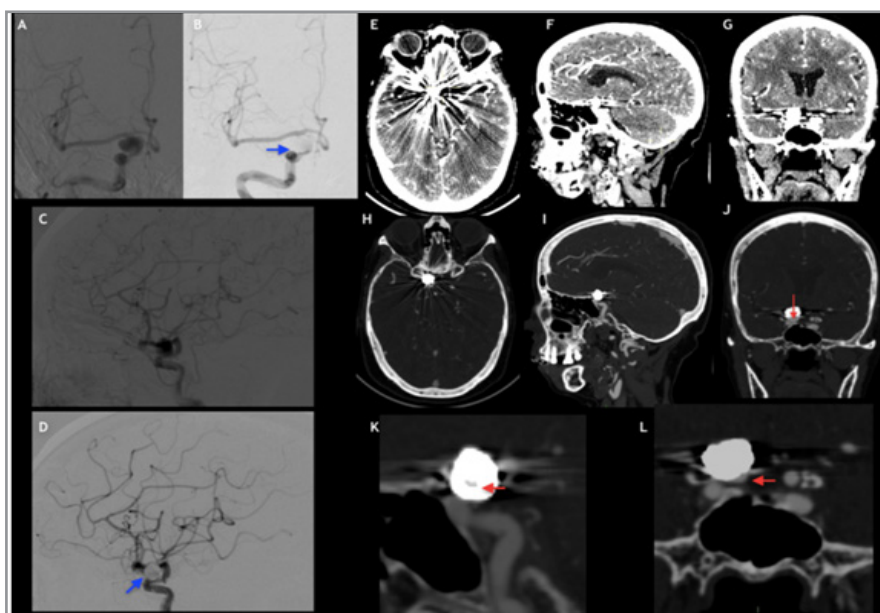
CTAMaR - DSA Discrepancy: A-D: DSA showing right paraclinoid aneurysm. Before embolization (A, C) and 3 months post-embolization (B, D). No evidence of residue/recanalization (arrow in B and D). E-G: CTA with traditional technique where metallic artifact prevents visualization of recanalization. H-J: CTAMaR showing 2.2mm recanalization in the aneurysmal neck in coronal section (arrow in J). K-L: MIP of CTAMaR exhibits contrast within the coil mass (arrow in K) and in the aneurysmal neck (arrow in L).
